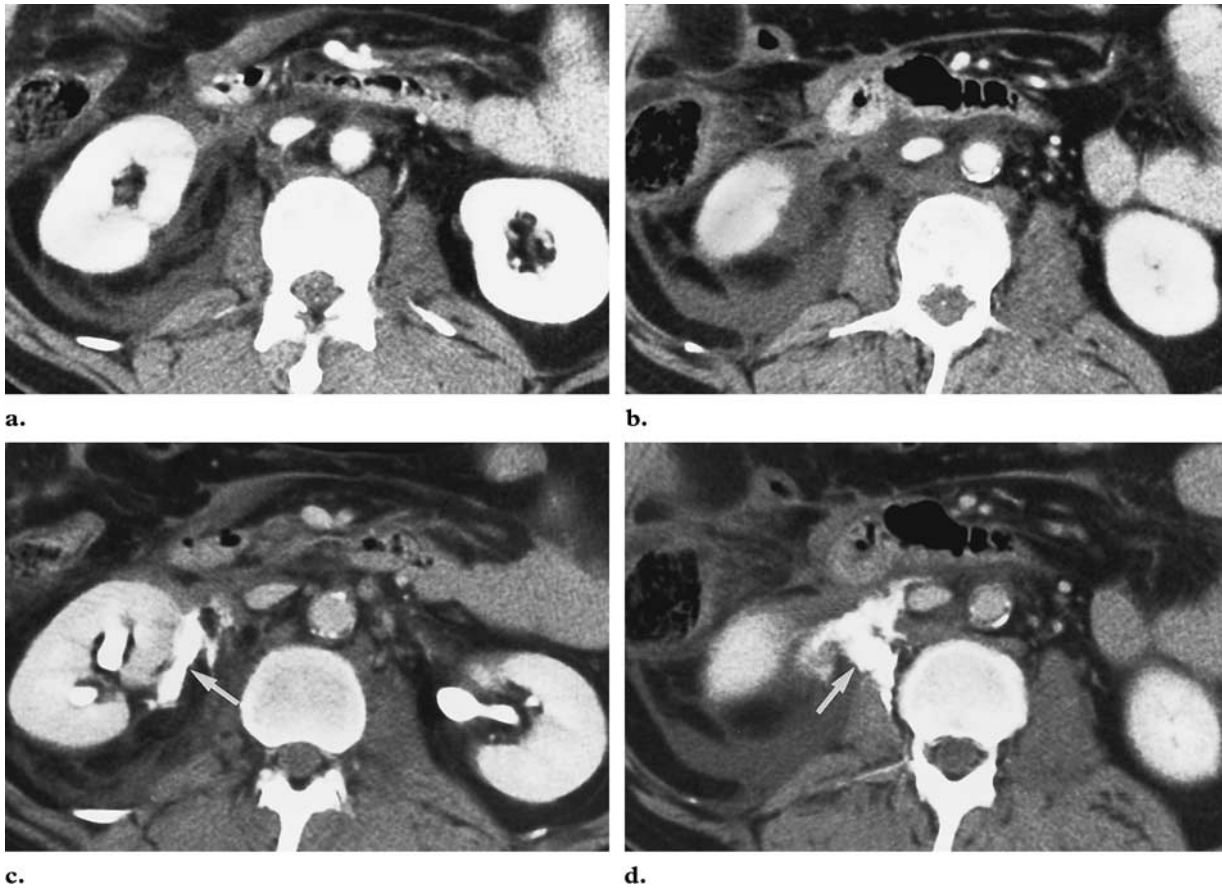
Avulsion of the ureteropelvic junction (category IV) in a 49-year-old man who had sustained blunt trauma. (a, b) Contrast-enhanced nephrographic-phase helical CT scans (a obtained at a higher level than b) through the lower pole of the right kidney demonstrate a perinephric fluid collection with no renal laceration. (c, d) Contrast-enhanced excretory-phase CT scans (c obtained at a higher level than d) demonstrate medial contrast material extravasation (arrow). No ureteral contrast material filling is noted. The patient underwent exploratory laparotomy for a mesenteric laceration. A diagnosis of ureteropelvic junction avulsion was made, and primary surgical repair of the ureter was performed.
